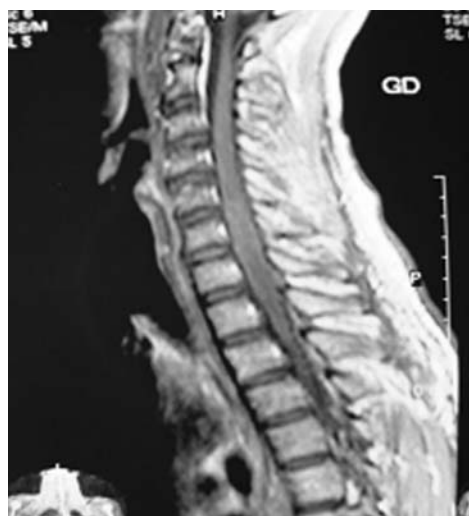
T1 MRI with contrast shows no enhancing cord expansion in C5-T2 level.
